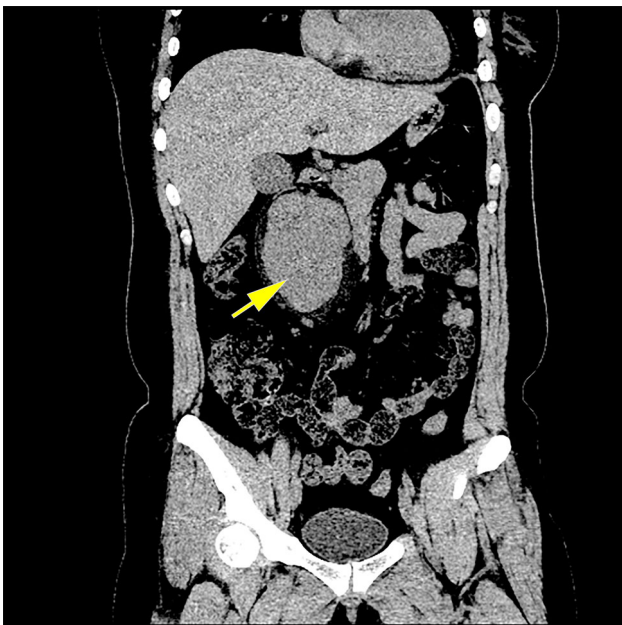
An axial computed tomography (CT) shows a solid, well-circumscribed mass (arrow) under the inferior hepatic edge
